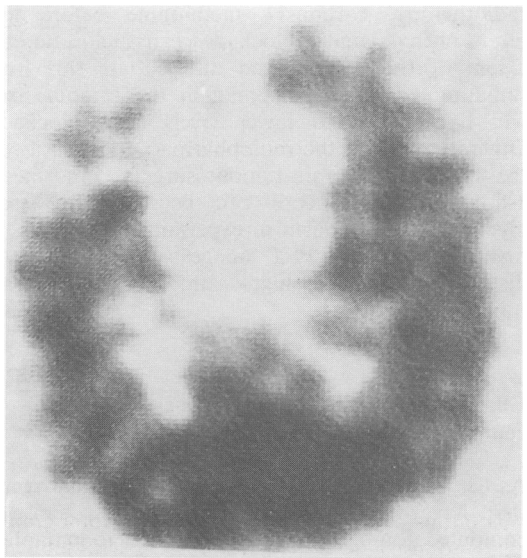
Cerebral SPECT image using technetium-99m HM-PAO, showing a large, central photon-deficient area in the frontal zone, now considered to be compatible with Pick's disease. The patient was an elderly man.
